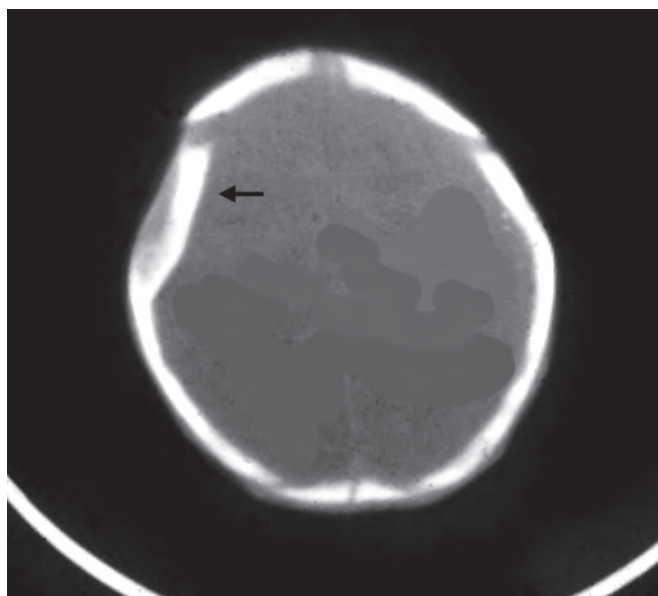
Pond fracture CT
